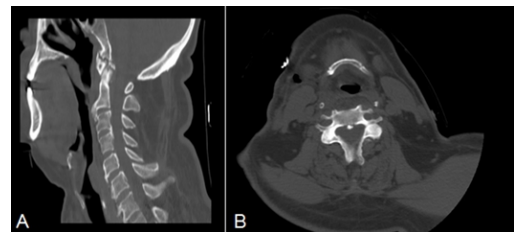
A-B: Post-operative sagittal CT images in Figure 3A and postoperative axial CT images in Figure 3B show no osteophytes and no narrowing in the hypopharyngeal and proximal esophageal passage.
